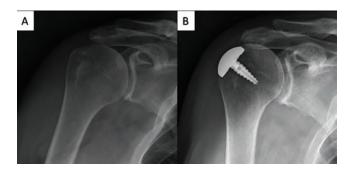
to 2B. Preoperative (2A) and postoperative (2B) radiographs of patient who had HemiCAP implant placed in the right shoulder for compensated rotator cuff arthropathy.
